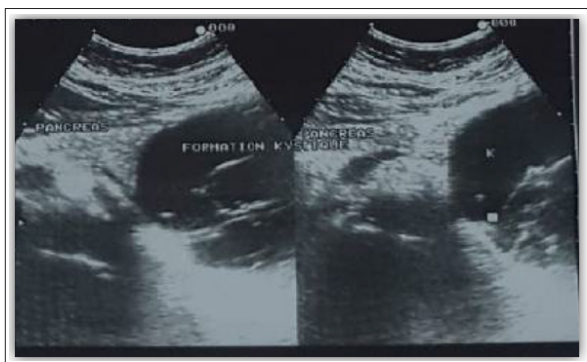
An Abdominal Ultrasound Showed a Multi-Lobular Anechoic Formation Approximately 10 Cm in Diameter Located In the Pancreatic Corporal-Caudal Area and Extending Anterior To the Spleen
